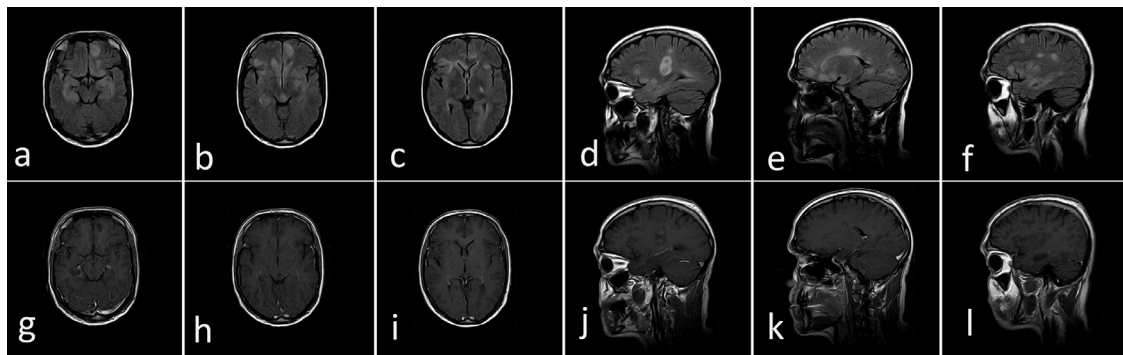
Fluid-attenuated inversion recovery images (a–f) of the brain showing multiple high-signal lesion in the brainstem, cortical, juxtacortical, and periventricular areas. Post-contrast T1-weighted sequences (g–l) showing enhanced lesion as target sign with low-signal dot in the center of lesion.
